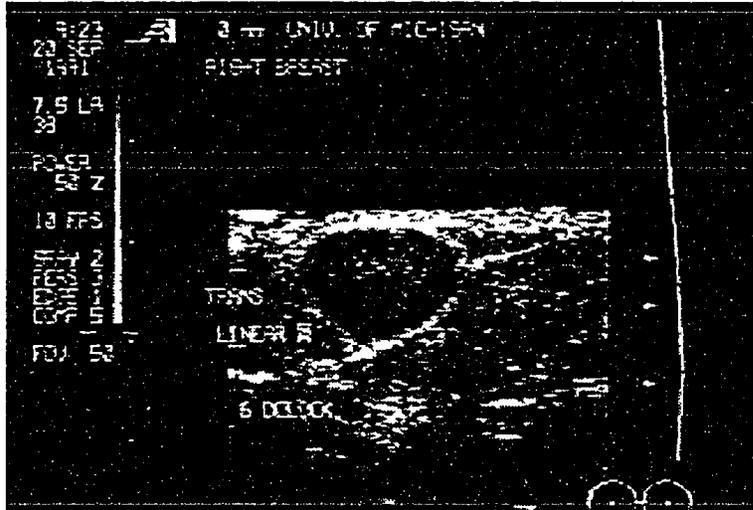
Ultrasound from patient C.
